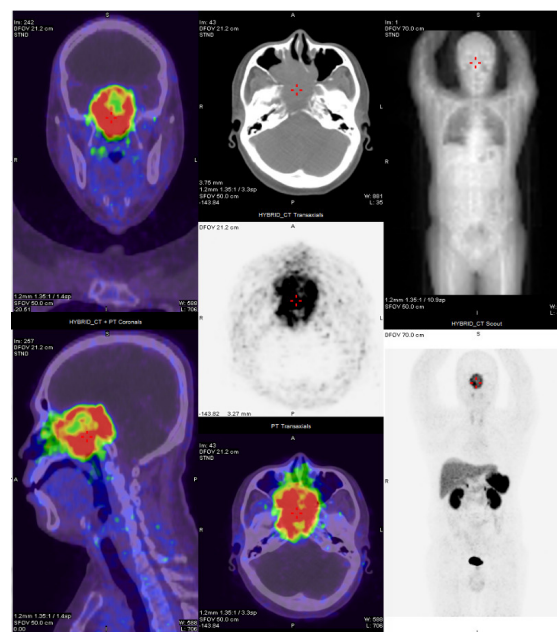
Gallium-68 DOTATATE PET/CT showed somatostatin receptor avid disease in the sphenoid region. Heterogenous Ga-68 DOTATATE uptake is seen at the large heterogenous soft tissue mass at the skull base likely arising from the sphenoid sinus region (highest SUVmax 17.0) with higher intensity of uptake seen at the peripheries and associated ametabolic area seen mainly centrally corresponding to hypodense necrotic areas. This mass measures approximately 6.9x5.3x5.6cm on CT. Anteriorly the mass extends to the paranasal sinuses and encroaches into the bilateral maxillary sinuses and anterior part of the nasopharynx as well as the bilateral optic canal and appears to compress the intra-cannicular portion of the optic nerves. It also involves the pterygoid plate, sphenoid, ethmoid, petrous-temporal bone medially and anterior part of clivus. Superiorly it erodes the sella turcica and extends into the cavernous sinuses, suprasellar cistern and appears to compress on the medial part of the temporal lobes bilaterally.
